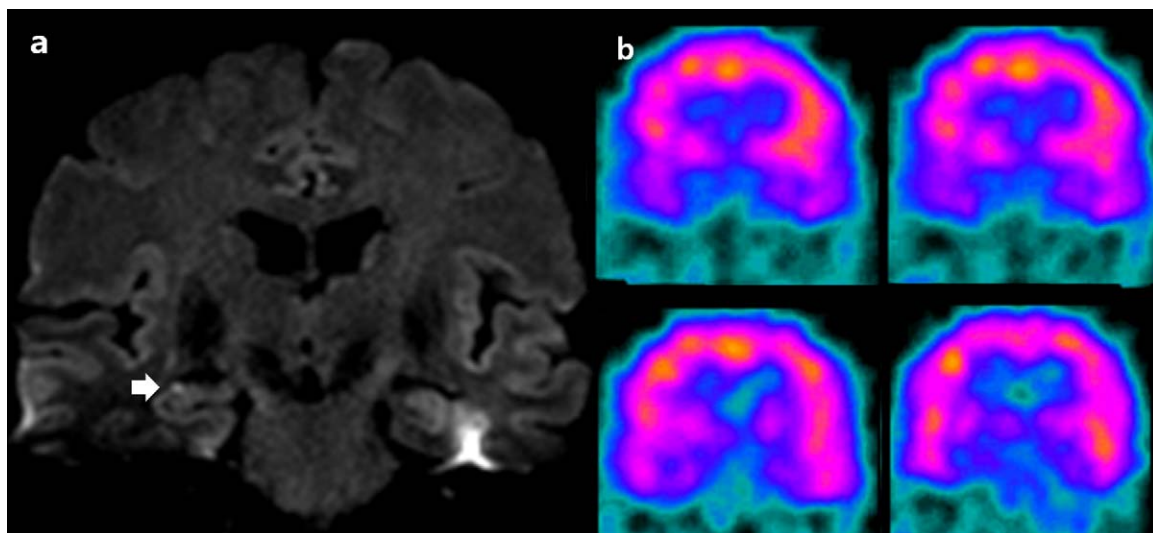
Brain MRI and SPECT of the patient. (a) Diffusion weighted image after 56 h from symptom onset reveals small dot-like high signal intensity in right hippocampus (arrow). (b) SPECT after symptom recovered decreased perfusion on both temporal lobes. And perfusion defect is observed in the right medial temporal lobe.
